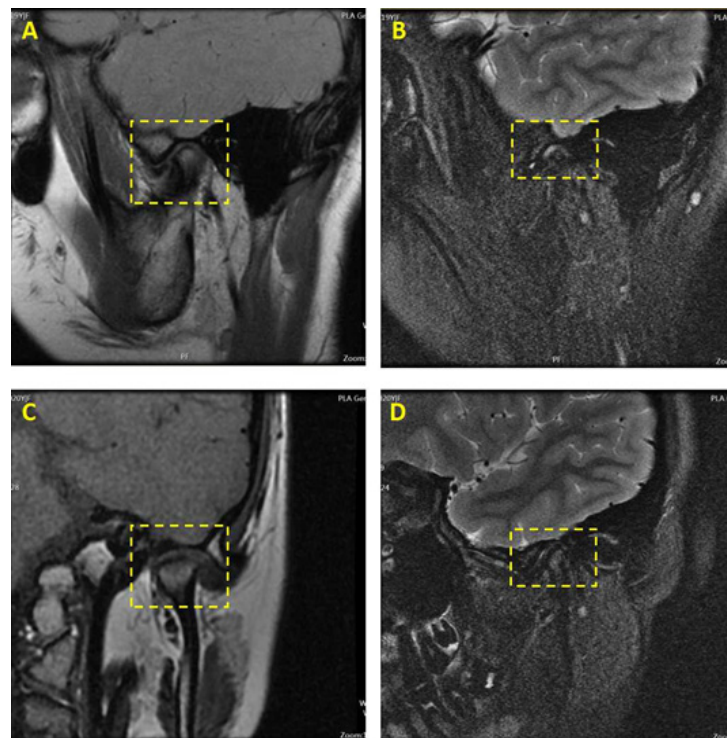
The MRI image of left TMJ. A and B was the pre-treatment image. C and D was the post-treatment image. Compared with A and B ,C and D showed reduced disc-condylar angle and disc-condylar distance effectively, less joint effusion after treatment.
